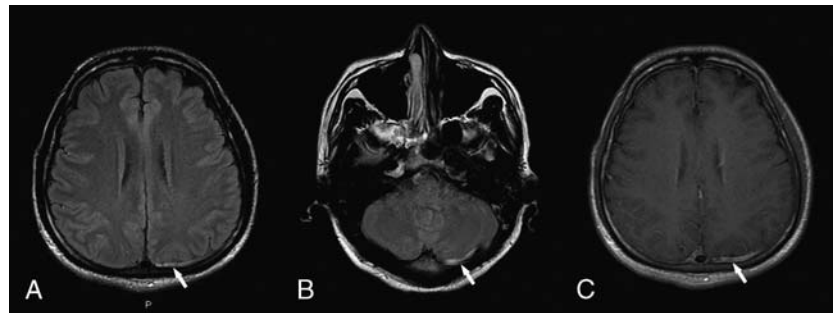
Postadmission follow-up brain MRI. FLAIR T2-weighted MRI images showing hyperintense cortical veins (A) and left transverse sinus (B). (C) Evidence of a cortical-vein filling defect in a contrast-enhanced T1-weighted image.
